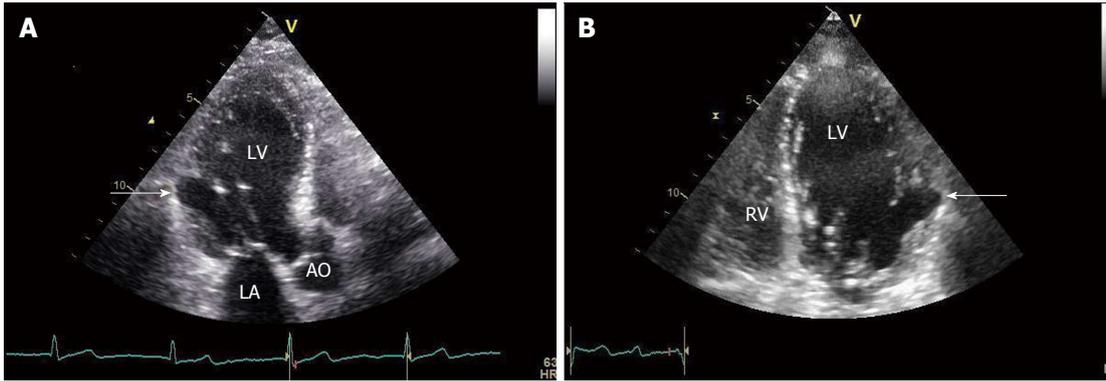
Echocardiography: Modified 4- and 3-Chamber view of the left ventricle lateral wall pseudoaneurysm (A and B, arrows). RV: Right ventricle; LA: Left atrium; AO: Ascending aorta; LV: Left ventricle.
